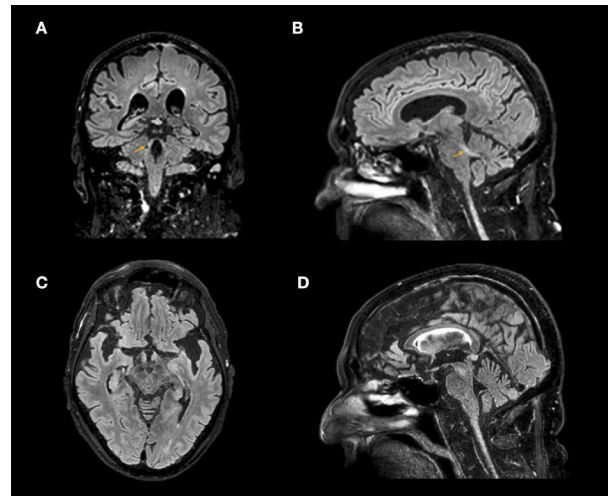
Brain MRI findings in patient 1. Superior cerebellar peduncles T2/FLAIR hyperintensity (A,B). Vermian atrophy (C,D)
